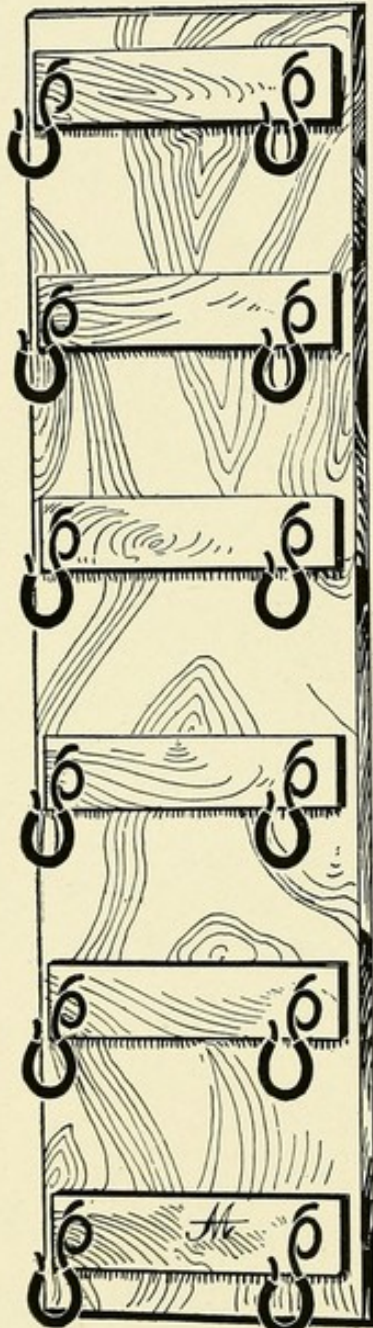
Tube rack for holding x-ray tubes.
